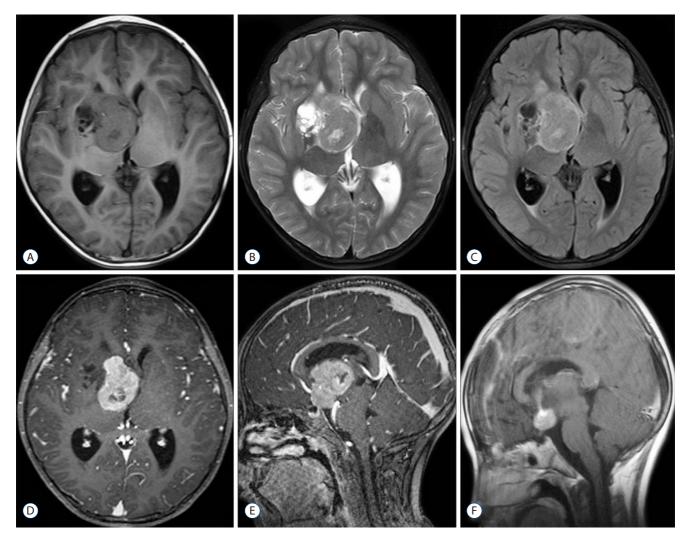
MRI showing a mass lesion in the right basal ganglia consisted of solid and cystic parts. The solid part manifesting isointense signal on T1-weighted (A), T2-weighted (B), and FLAIR (C) with heterogeneous enhancement (D and E); the cystic part showing hypointense signal on both T1-weighted (A) and FLAIR (C) and hyperintensity on T2-weighted images (B) without enhancement of the wall (D and E). Although the lower margin of the tumor touched the dorsum sellae dura, 'dura tail' sign was not noted (E). Postoperative MRI revealing that most of the tumor has been resected and the residual part detached from the dorsum sellae (F). Subdural fluid accumulation in the surgical region was also detected (F). FLAIR : fluid attenuation inversion recovery, MRI : magetic resonance imaging.
